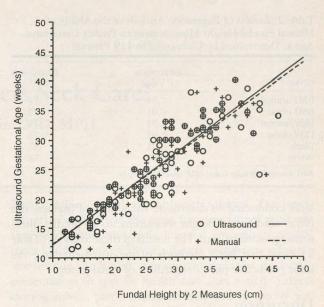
Comparison of manual and ultrasound fundal height measures with gestational age as determined by usual ultrasound measurements in 119 patients.
